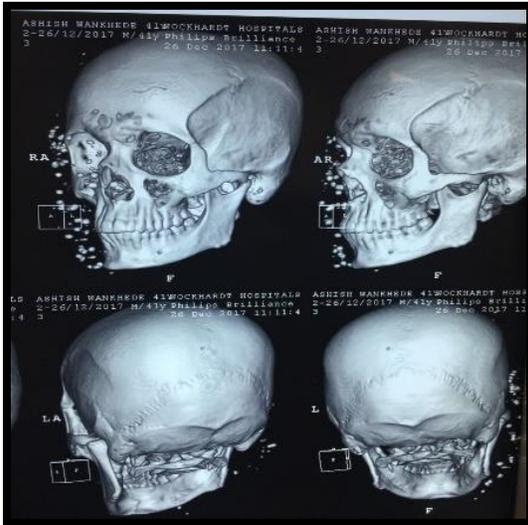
Showing 3D CT Images of Patient
